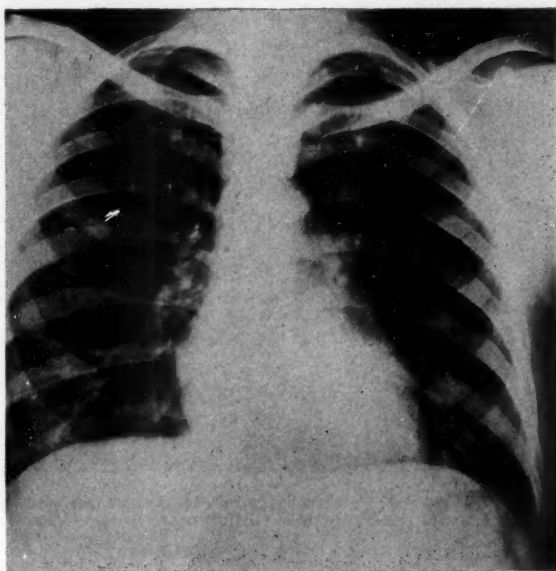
Photograph of chest x-ray showing round density in right third interspace interpreted as metastatic lesion.
